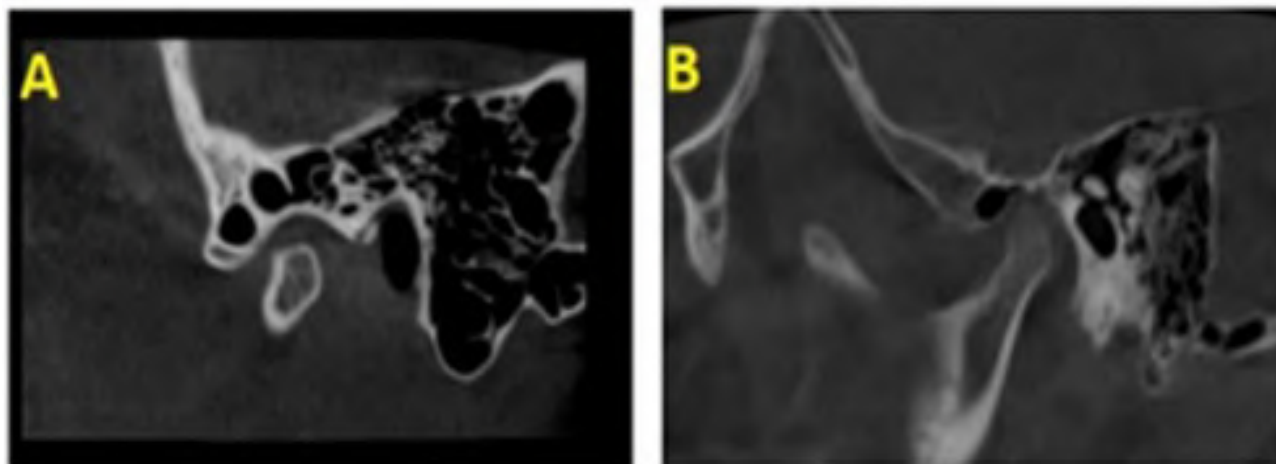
Unilocular ZACD in CBCT images.
